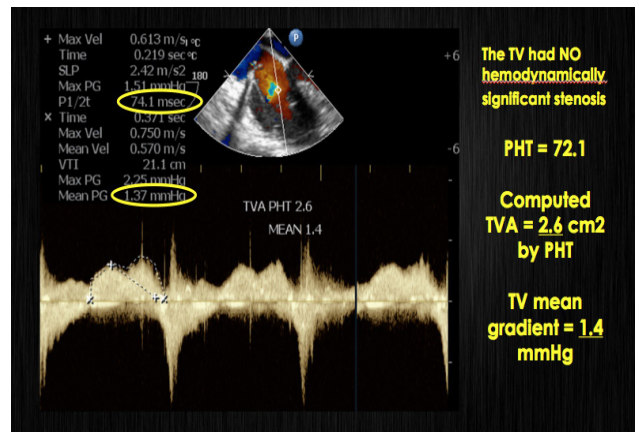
Post-operative transesophageal echocardiogram showing no hemodynamically significant tricuspid stenosis with computed tricuspid valve area (TVA) of 2.6 cm² by pressure half time (PHT) with a tricuspid valve mean gradient of 1.4 mmHg
